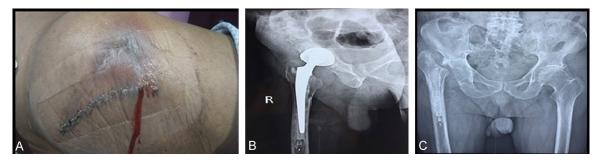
Clinical photograph of operated hip of a patient who developed deep wound infection with history of pus discharge (A); AP radiograph of pelvis including both hips showing infected bipolar prosthesis with grade 3 acetabular erosion just before removal (B) and Postoperative AP radiograph of the same patient after Prosthesis removal due to deep wound infection (C).
